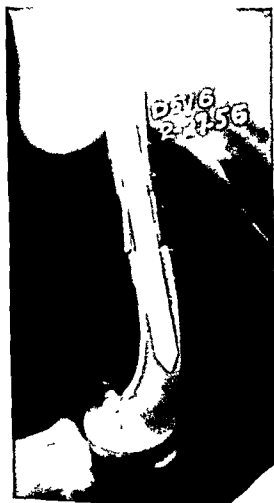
Freeze dried bone graft fixed with an intramedullary nail. Roentgenogram immediately after nailing.
